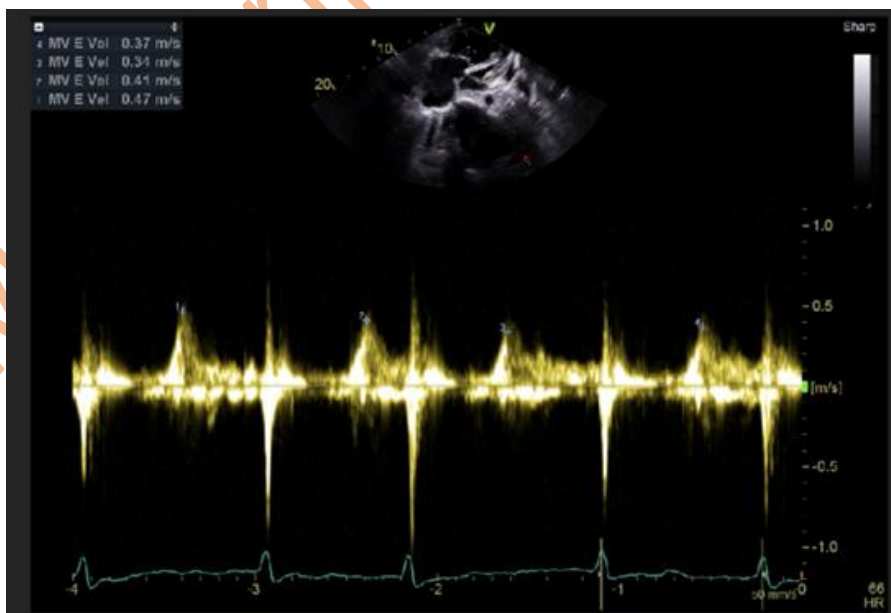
Echocardiogram demonstrating relatively low E-wave velocity (all < 0.5 m/s), indicating impaired early diastolic filling, consistent with diastolic dysfunction, likely grade I (impaired relaxation)
